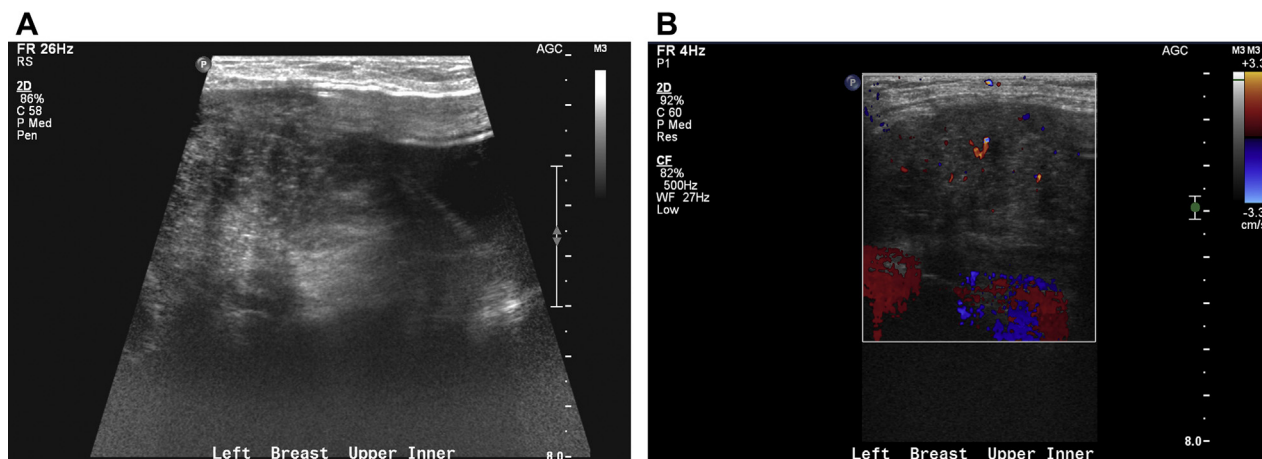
(A) Ultrasound images of the left upper inner quadrant shows a 7.6-cm hypoechoic mass with irregular margins and posterior acoustic shadowing. (B) Color Doppler ultrasound image shows increased vascularity within and around the lesion.
